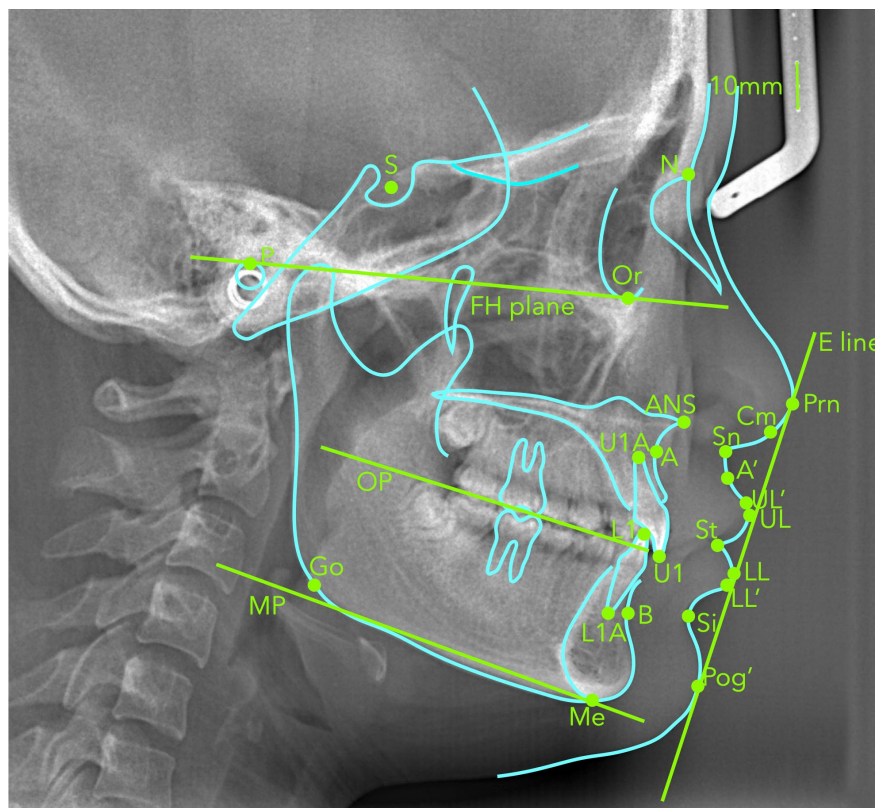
The landmarks. The landmarks of the lateral cephalometric radiographs: S, sella; N, nasion; P, porion; Or, orbitale; A, subspinale; ANS, anterior nasal spine; B, supramental; Me, menton; Go, gonion; U1, upper incisor; U1A, upper incisor apex; L1, lower incisor; L1A, lower incisor apex; Prn, pronasale, the most prominent point of the nasal tip; Cm, columella, the most anterior point of the columella nasi; Sn, subnasale; the intersection point of the columella crest and the upper lip; A', upper lip concave point; UL', upper vermilion margin, UL, the most anterior point of the upper lip; St, stomion, the midpoint of the labial fissure; LL, the most anterior point of the lower lip; LL', lower vermilion margin; Si, the most concave point of the mentolabial sulcus; Pog', the most anterior point of the chin. Planes involved: FH plane, Frankfort horizontal plane, formed by the connecting line between P and Or; OP, occlusive plane, formed by the line that equally divides the occlusal contact points of the posterior teeth; MP, mandibular plane, the line passing Me and tangent to the lower margin of the mandibular angle; E line, the line joining Prn and Pog'.
